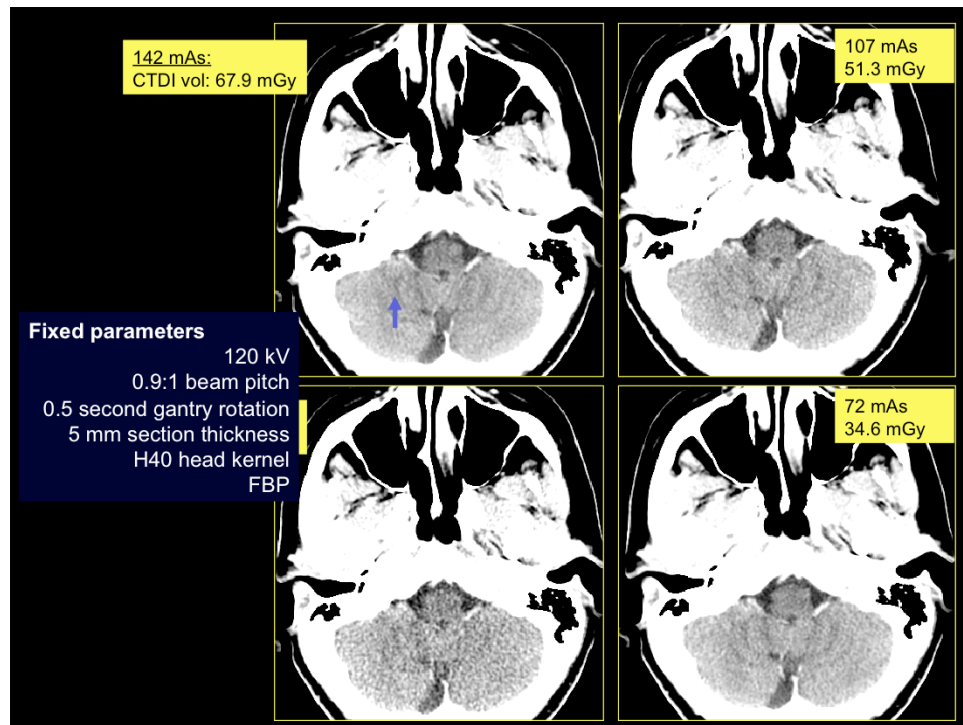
Head CT acquired at various tube currents with a limited scan length of 10 cm to limit the total radiation exposure. increased image noise in low dose image at 35 mAs (16.7 mGy) limits the visibility of grey white matter (arrow) in the cerebellum surrounded by thick cranial bones.
